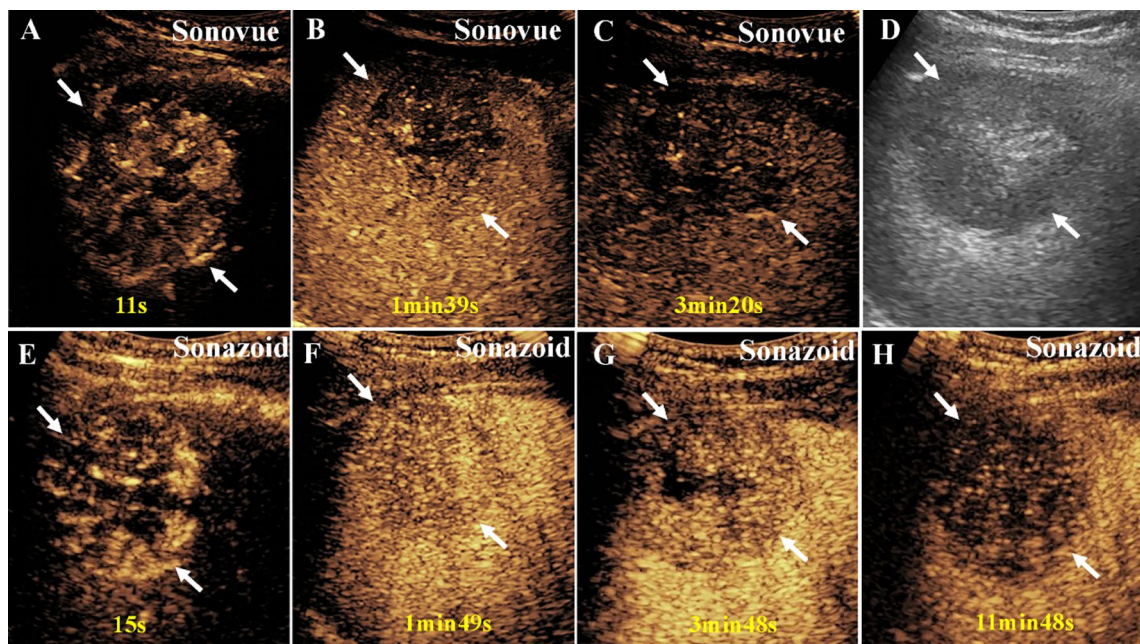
A 53-year-old male underwent both of the contrast-enhanced ultrasound examinations, and hepatocellular carcinoma was subsequently diagnosed by pathology. A The arterial phase image shows heterogeneous arterial hyperenhancement (APHE) of the lesion (arrow) after injection of SonoVue. B–C A mild washout (arrow) was detected in the delayed phase after injection of SonoVue. D Conventional ultrasound demonstrated a 54 mm focal lesion in the right lobe
